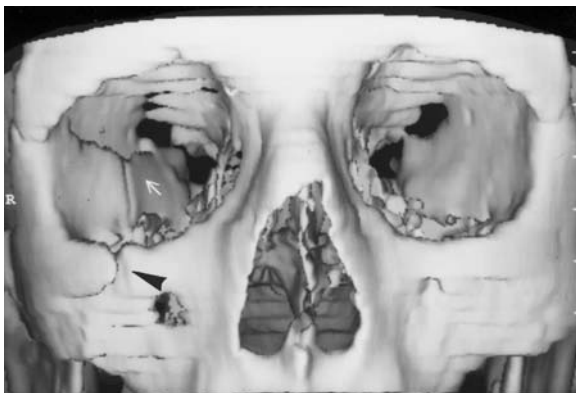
A 54-year-old man with facial injury after a car accident. Diagnosis: orbital wall fracture. CT 3D-reconstruction: this image modality enables a lucid view of the fracture extending from the lateral right wall (white arrow) to the frontozygomatic suture and the orbital floor (arrowhead). (With permission of MÜLLER-FORELL and LIEB 1995b)
